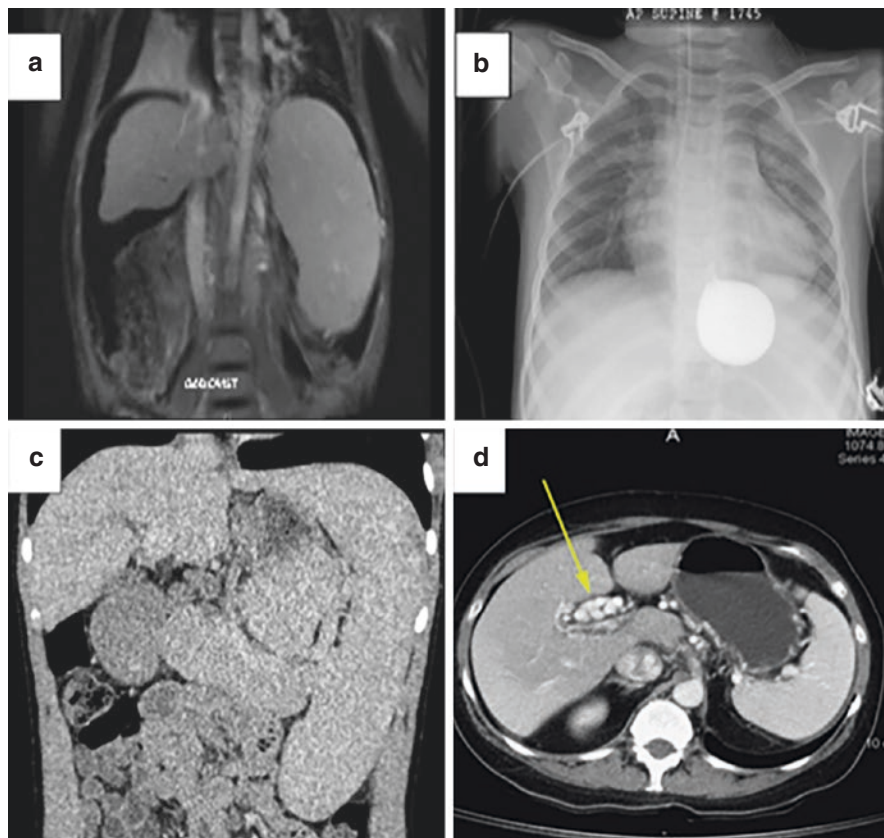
MRI appearances of an adolescent with liver cirrhosis, ascites and splenomegaly (a). Chest X-ray image of a patient with inflated Sengstaken-Blakemore gastric balloon for management of variceal bleeding (b). MRI imaging of a young person with Joubert's syndrome with fibrotic liver and significant splenomegaly (c). MRV imaging of a child with PVT and formation of portal cavernoma (arrow) with ascites following a GI bleed (d)
